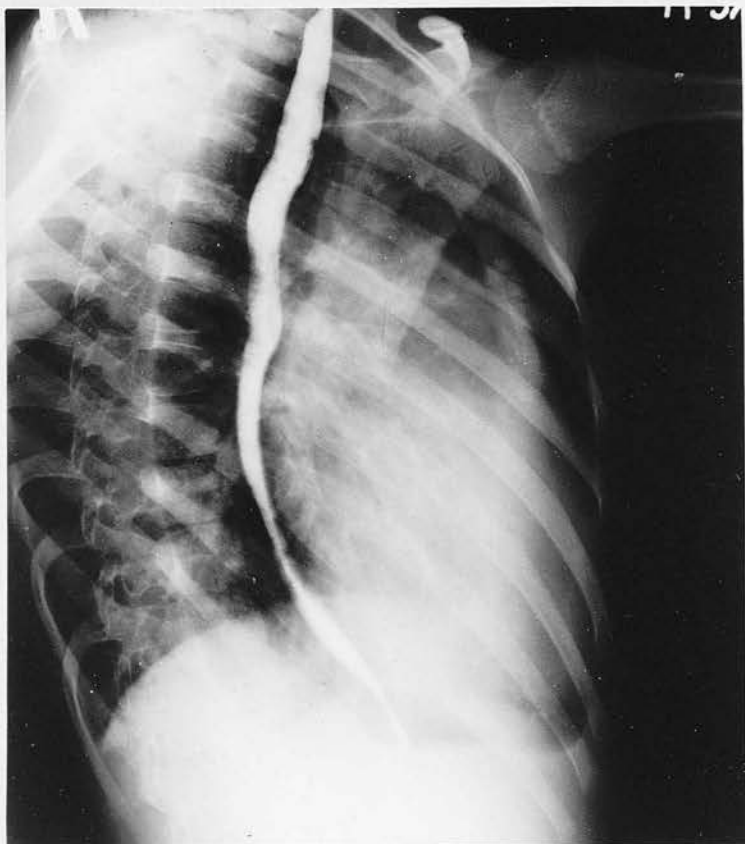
Radiograph of Case 46. Large Patent Ductus aged 9yrs.
